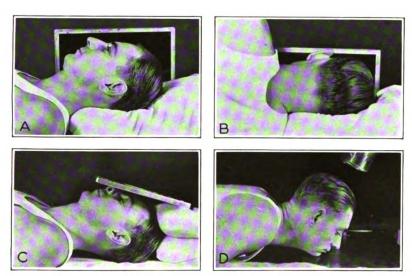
A, position for lateral exposure of the cranium with the patient supine. The head is supported by a non-opaque pillow. The x-ray film is placed vertically alongside the head, and the rays directed horizontally. B, position for a film of the frontal region with the patient in the lateral position; there is a non-opaque pillow under the head. The film is vertical, and the rays directed horizontally. C, position for a film of the frontal region with the patient supine, the film over the forehead supported by sand bags, and the rays directed vertically from beneath the table top. D, position for vertex-submental exposure of the cranium to show the cranial base, the petrous portions of the temporal bones, and the sphenoid sinuses. The chin is elevated as much as possible and rests on top of the Potter-Bucky diaphragm. By angling the tube toward the feet, the central rays are directed perpendicularly to a plane through the external auditory meati and the floors of the orbits.
